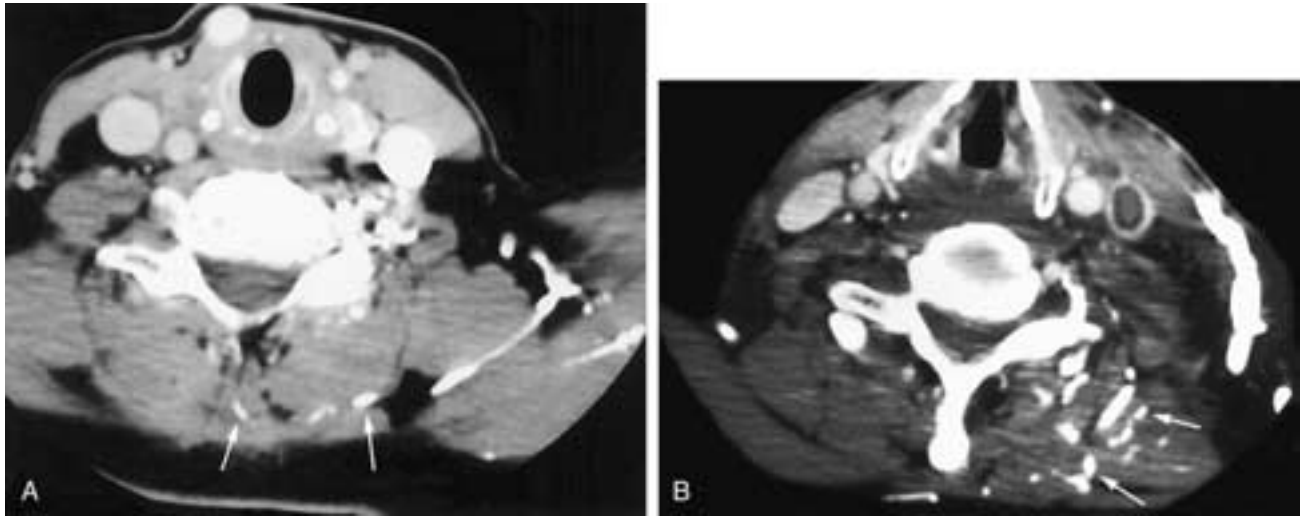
Axial contrast-enhanced CT scan (A) on a normal patient shows intense enhancement of the muscular vessels of the posterior neck (*arrows*). Although this could be seen in a patient with venous obstruction, there was no such obstruction and these were not collateral vessels. The contrast was administered by rapid injection, and the patient was scanned during contrast administration (1 second per scan). The vessels are probably veins opacified by reflux from the internal jugular vein (note the asymmetry of jugular opacity). Axial contrast-enhanced CT scan (B) shows a lucent thrombus in the left internal jugular vein and enhancement of the vein wall due to contrast in the vasa vasorum. There are also numerous large collateral venous channels (*arrows*) in the lateral and posterior left neck.
